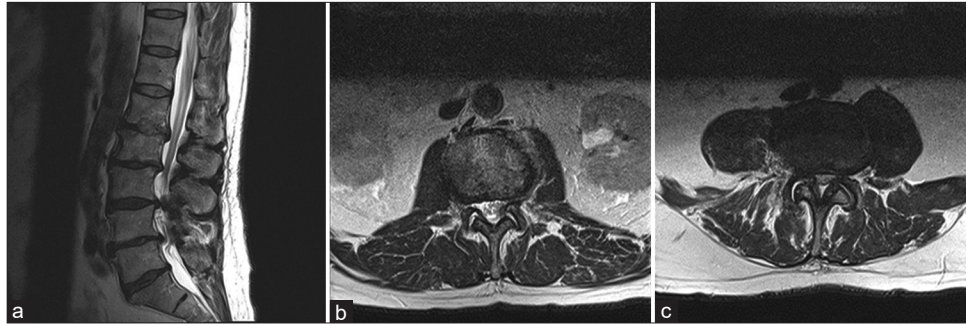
Prelaminectomy T2 MRI (a) sagittal lumbar spine, (b) axial L1-2 spine, (c) axial L3-4 spine multilevel degenerative changes are noted resulting in severe canal stenosis particularly at L2–L3 and L3–L4 and slightly less pronounced canal narrowing at L4–L5 and L1–L2. Multilevel foraminal narrowing are noted from L1 to S1.
